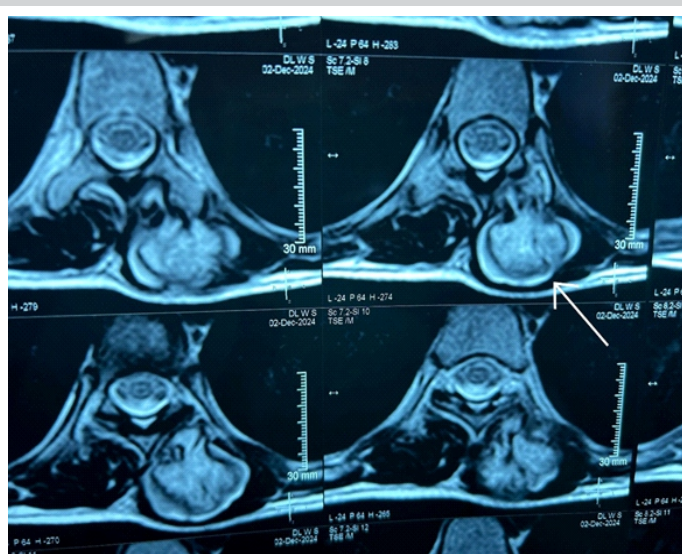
Magnetic resonance imaging film (T2-weighted axial image) shows a well-defined lesion with heterogeneous intensity arising from the transverse process of D8 vertebra, causing compression of the spinal cord on the left side.
